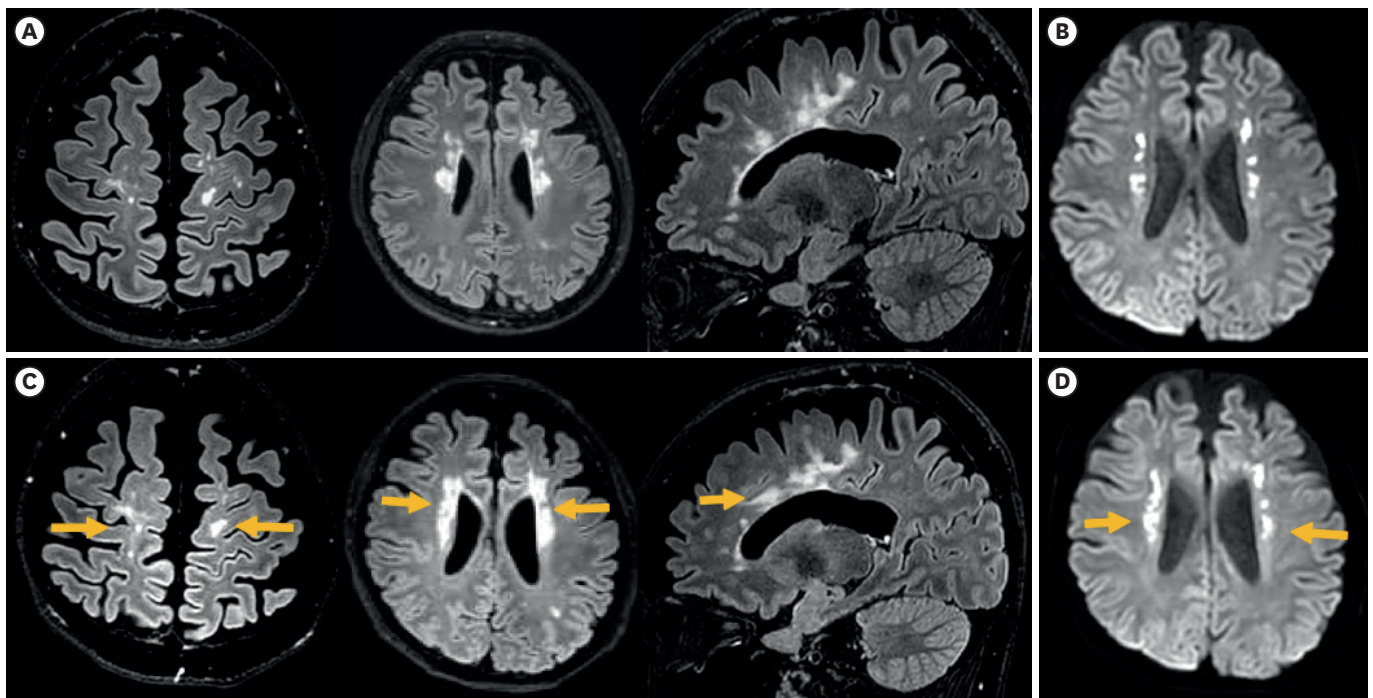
Serial MRI showing progressive white matter lesions. (A) Initial brain MRI demonstrates multiple T2 hyperintense lesions involving the juxtacortical and periventricular white matter, fulfilling dissemination in space according to the 2017 McDonald criteria. (B) DWI shows diffusion restriction in the periventricular lesions. (C) Follow-up MRI obtained one year later demonstrates progression of the white matter lesions, with increased extent (arrows), along with mild frontal lobe atrophy. (D) Follow-up DWI shows persistent diffusion restriction with progression of the periventricular lesions (arrows), an unusual finding for multiple sclerosis that prompted reconsideration of the diagnosis.
